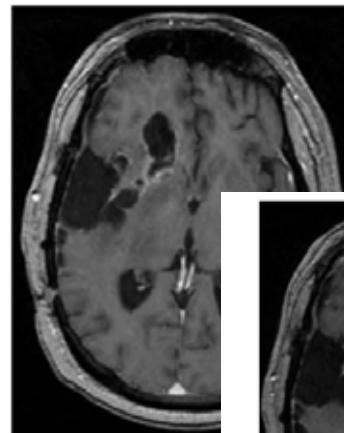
Axial T1-weighted MR image 3 months after completion of PRD showing regression within the treatment field and mass effect, and enlargement difference in anatomy visible in axial slices.
